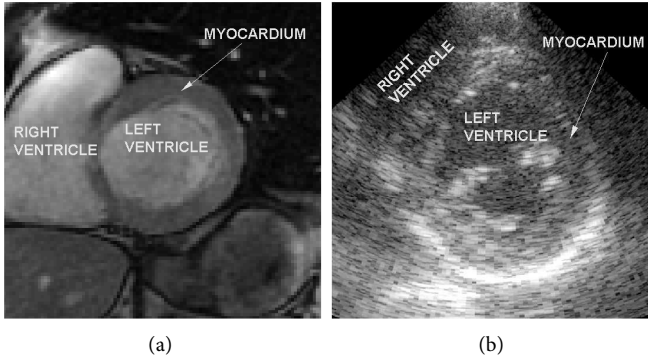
Short axis view of the left ventricle from 2D echocardiography (a) and cardiac MRI (b).
